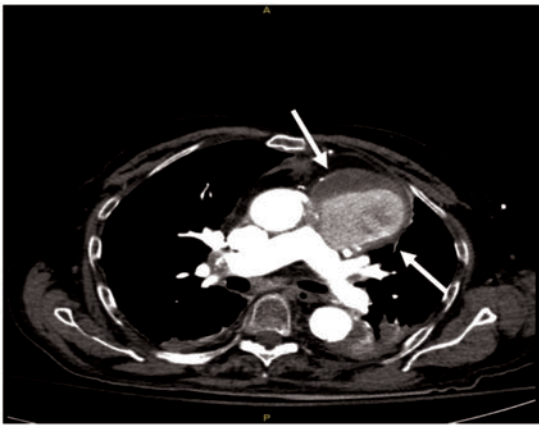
CTA imaging demonstrates the expanding pseudoaneurysm with layering of contrast in the true lumen in transverse view. The aforementioned compression on the lateral wall of the right ventricle can be observed with addition of bibasilar atelectatic changes. White arrow indicates the SVG pseudoaneurysm filled with ~70% contrast.
